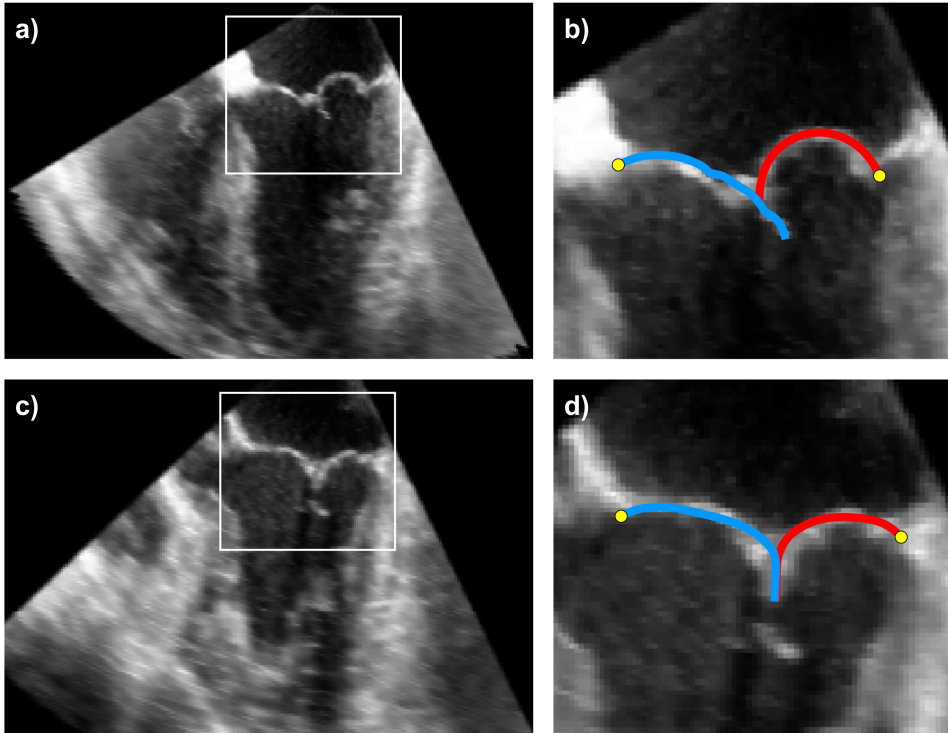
Morphological comparison of computed systolic leaflet configuration in pathological model with echocardiographic images: a) region of interest in pre-operative image; b) cross-sectional view of computational model after virtual repair with neochordae implantation into the posterior leaflet superimposed to pre-operative echocardiographic image; c) region of interest in post-operative echocardiographic image; d) cross-sectional view of computational model after virtual repair with neochordae implantation into the anterior leaflet superimposed to post-operative echocardiographic image
